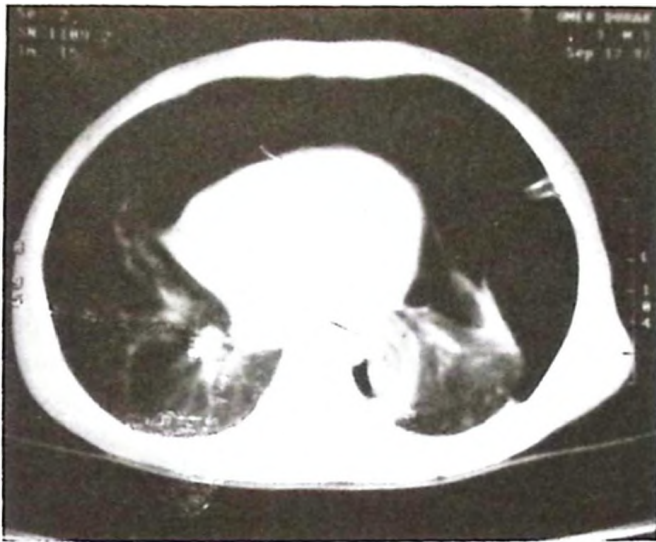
Thorax CT image showing pneumothorax and air-filled areas between the parietal and visceral pleura in the left lung field.
